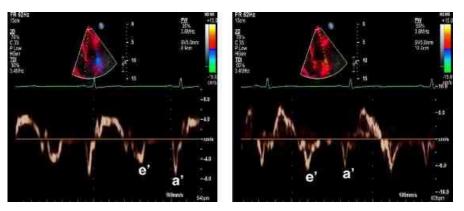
Septal (left) and lateral (right) tissue Doppler recordings.
